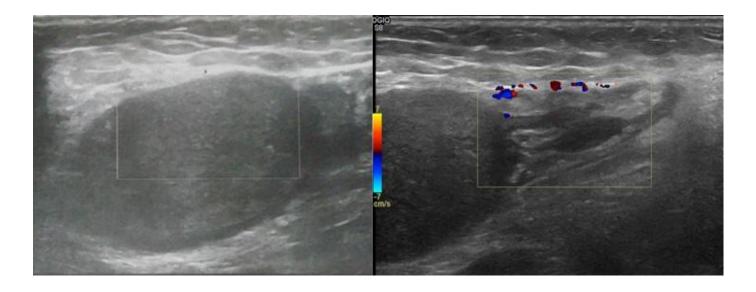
Colour Doppler showing absent flow signals in testis and its vascular pedicle
